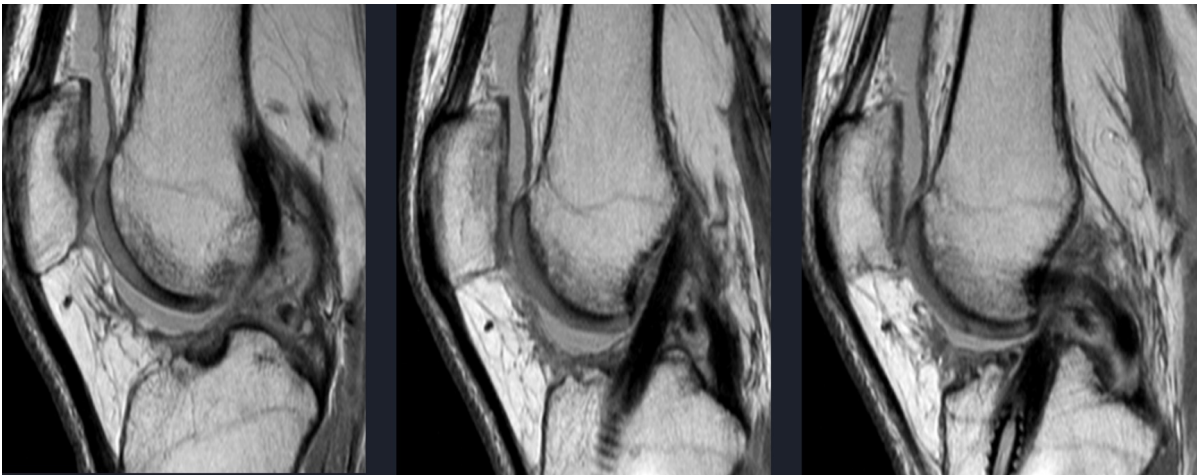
Sagittal T2W MRI showing the correct positioning of the tibial and femoral tunnels and appearances of the normal graft.
